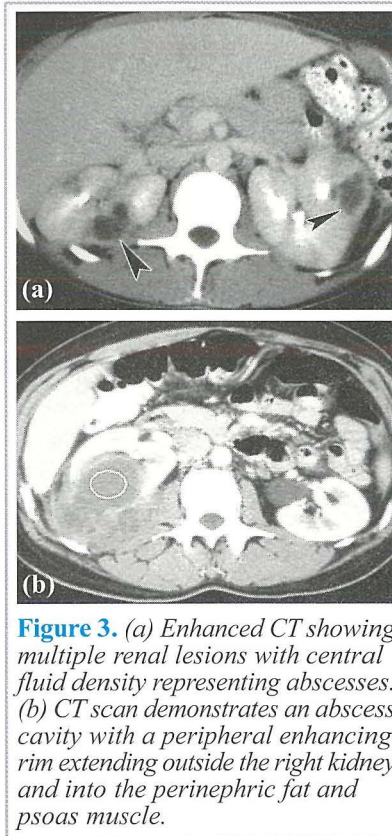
(a) Enhanced CT showing multiple renal lesions with central fluid density representing abscesses. (b) CT scan demonstrates an abscess cavity with a peripheral enhancing rim extending outside the right kidney and into the perinephric fat and psoas muscle.
